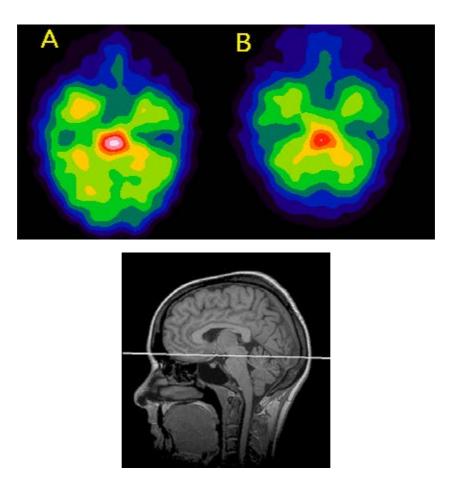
An example of [123I] nor- $\beta$ -CIT SPECT imaging of the midbrain Kuopio University Hospital Department of Clinical Neurophysiology. A: Healthy control subject, B: patient with MDD. In the sagittal T1-weighted anatomical MRI scan, the white line indicates the plane of midbrain imaging cutting through dorsal and median raphe nuclei.
